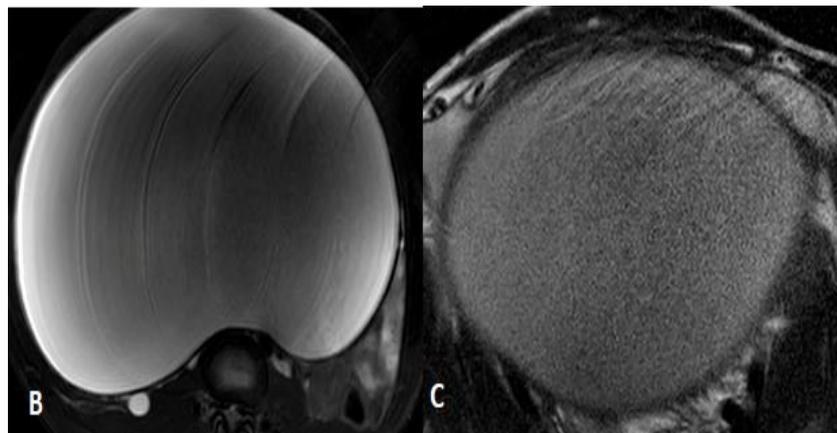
(B)(C) In the same patient, MRI-pelvis T2 axial & T2 axial FAT-SAT images show a large, well-defined T2 hyperintense lesion in the abdominopelvic cavity suggests the possibility of the neoplastic ovarian lesion. On HPE the lesion was identified as mucinous cystadenoma
